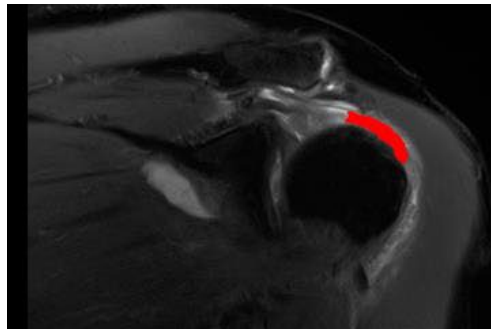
Segmentation (red) of the tear region in a coronal MRI
